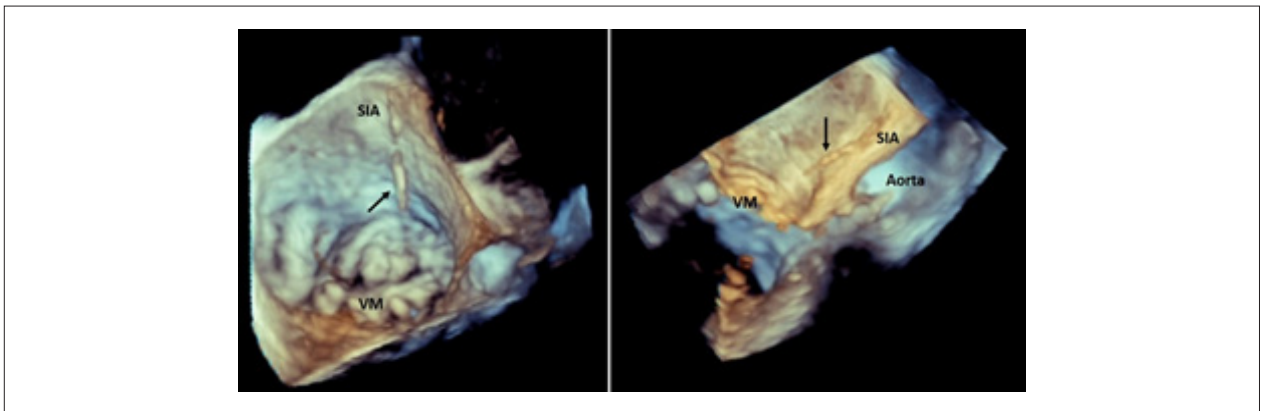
3D transesophageal echocardiogram images confirm the presence of an anomalous chord connecting the A3 segment of the mitral valve (MV) to the middle region of the interatrial septum (IAS).
